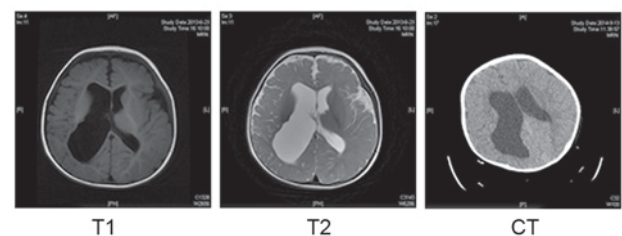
Brain MRI and CT radiograph of Case 3 with pyridoxine-dependent epilepsy. Brain MRI (T1- and T2-weighted imaging) indicated right periventricular leucomalacia involving subcortical white matter, accompanied by gliosis. Brain CT revealed similar results. MRI, magnetic resonance imaging; CT, computed tomography.
